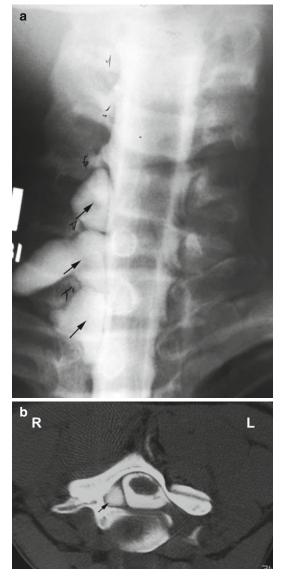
CT Myelography showing root avulsion. (a) Myelography of the Cervical spine in a patient with multiple root avulsions (*arrows*). (b) Example of CT myelography in a patient with severe right brachial plexus injury. Note avulsed root on the right (*arrow*)
